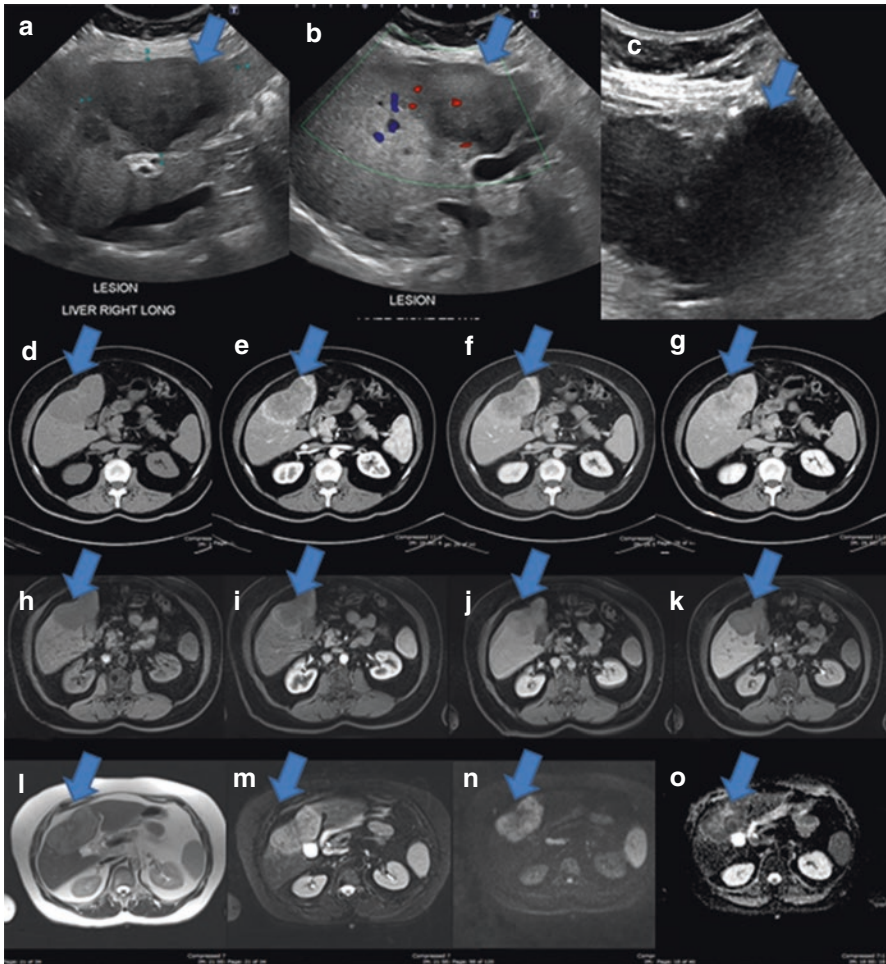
Intrahepatic cholangiocarcinoma (iCCA) with mass-forming growth pattern (blue arrows), which is the most common subtype of iCCA. Grayscale (a) and color Doppler (b) US images obtained as initial screening, demonstrating a hypoechoic mass with hypovascularity. US was also used as guidance (c) for percutaneous biopsy later in the management. The echogenic linear foci correspond to the biopsy needle within the lesion. Multiphasic CT images with iodinated contrast in the non-contrast (d), arterial (e), portal venous (f), and 3-minute delayed (g) phases confirmed the large hepatic mass with typical findings of peripheral arterial hyperenhancement and delayed progressive central enhancement. The mass is associated with capsular retraction and regional hepatic atrophy. Multiphasic MR images with a hepatobiliary contrast agent in the non-contrast (h), arterial (i), portal venous (j), and 20-minute delayed hepatobiliary phase (k) demonstrated the hepatic mass similarly to CT. Of note, no contrast uptake is seen on the hepatobiliary phase in the lesion, confirming non-hepatic cellular content. The mass shows mild T2 hyperintensity on the nonfat-saturated (l) and fat-saturated (m) T2 sequences, as well as marked restricted diffusion with DWI hyperintensity (n) and ADC hypointensity (o)
